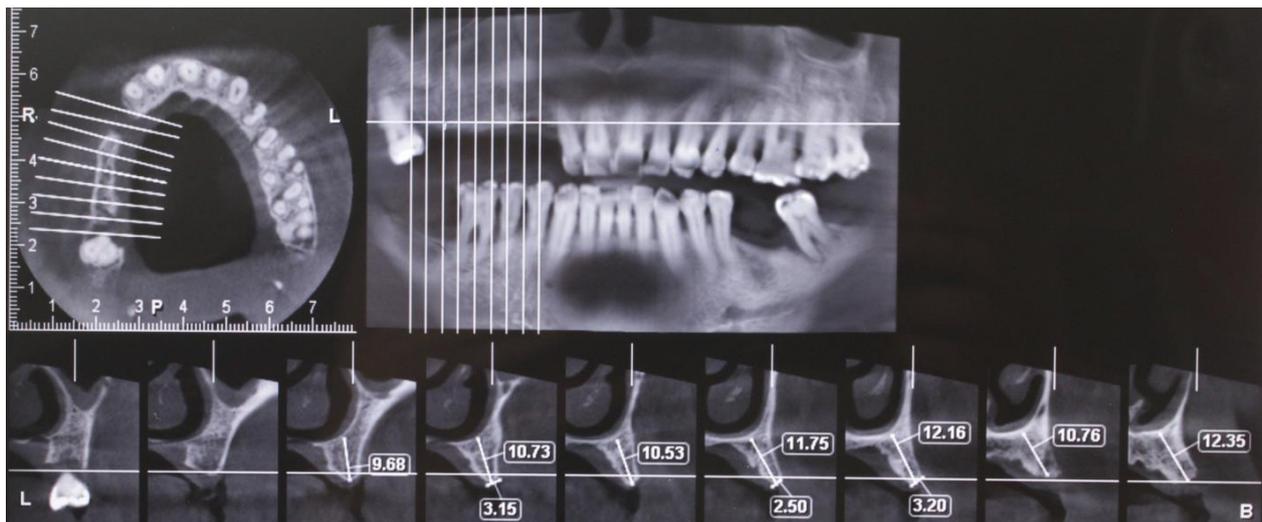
CBCT view of the maxillary right quadrant
